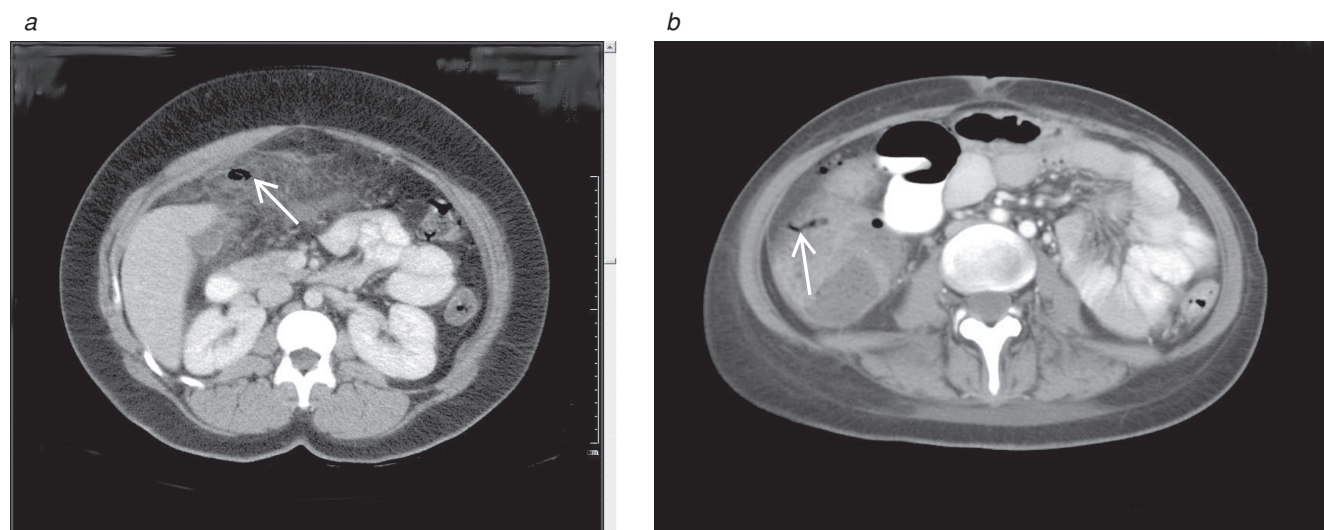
(a) An abdominal computed tomographic (CT) scan of an elderly patient with a history of vascular disease and worsening abdominal pain over a 3-day period showing diffuse inflammation and right upper quadrant extraluminal air (white arrow). The patient underwent emergency exploration, and ischemic perforation of cecum was found. Right hemicolectomy and temporary diverting ileostomy were performed. (b) An abdominal CT scan of a patient with a history of Crohn disease and worsening abdominal pain demonstrating thickening of the colonic wall with both intramural and extramural air (white arrow). The patient was treated with emergency total abdominal colectomy for pancolitis with creation of a temporary diverting ileostomy.
